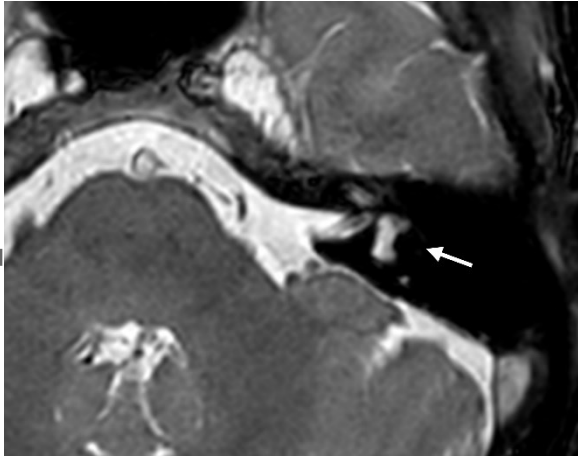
67-year-old female with left labyrinthitis ossificans. 3D heavily T2-weighted image showed decreased signal intensity in the left lateral semicircular canal (arrow), consistent with left labyrinthitis ossificans.
